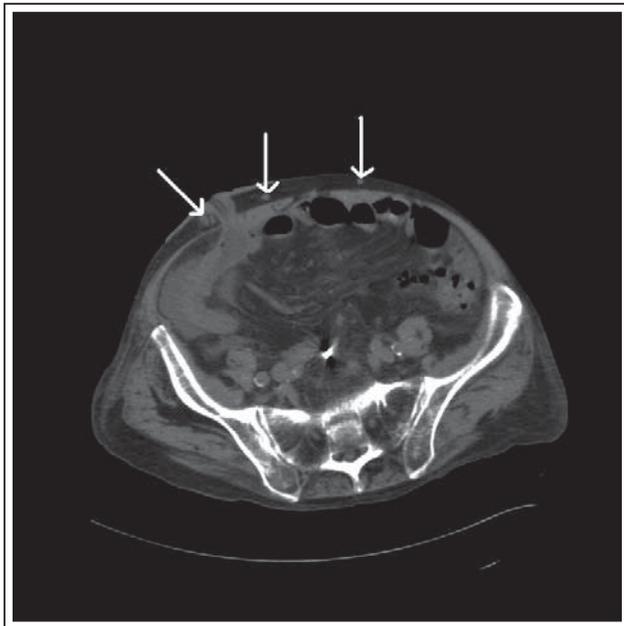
Non-contrast computed tomography scan of the abdomen revealing marked peristoma collateral vessel/varices formation secondary to portal hypertension.
